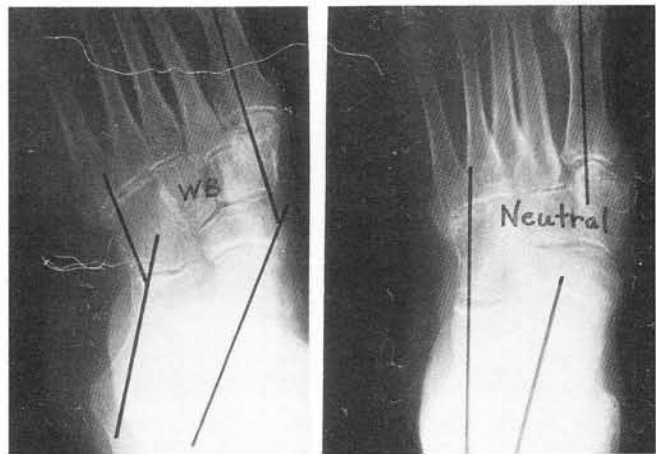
Dorsal plantar weight-bearing and neutral position radiographs in a very active 73-year-old patient with end stage peritalar subluxation secondary to long standing tibialis posterior tendon dysfunction. Secondary changes are seen throughout the medial column articulations and even the tarsometatarsal articulations, however, the neutral position film demonstrates excellent restoration of alignment. Clinically, the midtarsal joint had excellent motion without pain or crepitus. A large callus beneath the medial column was a primary symptom making any type of orthotic or brace intolerable in this patient.
